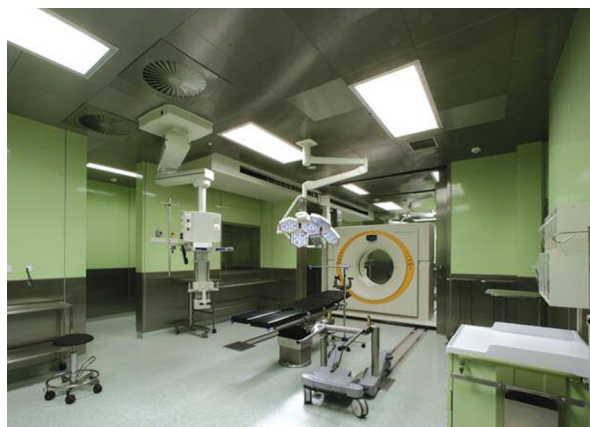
Operating room with CT - SOMATOM Sensation Open
